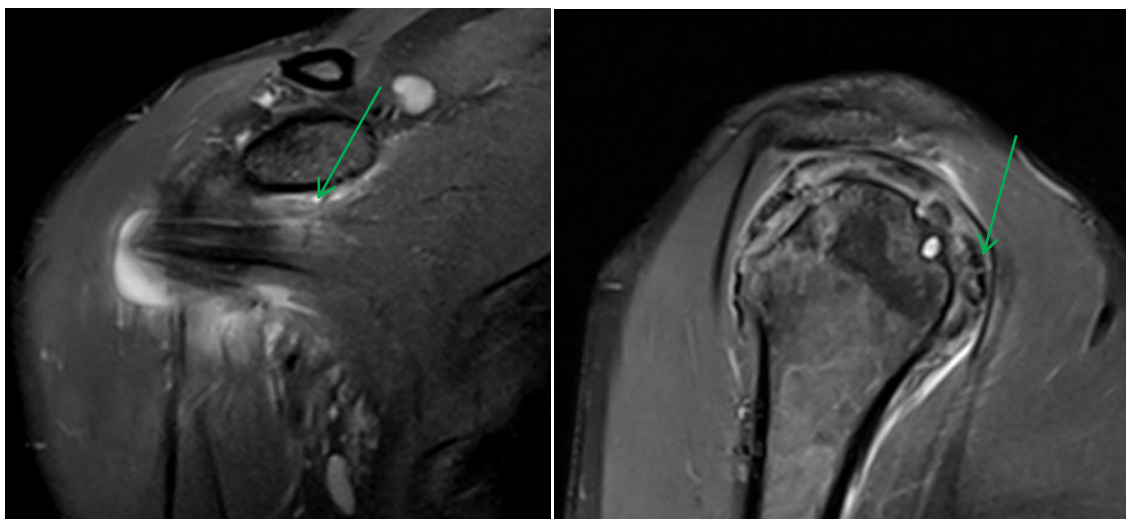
Above PD-FAT SAT MR images show partial tear at myo-tendinous junction (green arrows) of subscapularis muscle.
